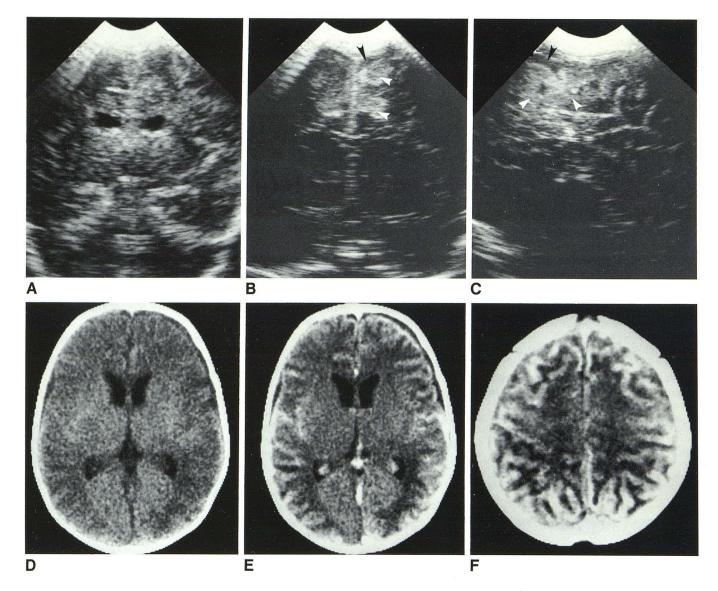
Case 1. A, Coronal sonogram with 5.0 MHz transducer. Mildly enlarged ventricles and abnormal brain parenchymal echogenicity. Magnified coronal (B) and sagittal (C) sonograms with 7.5 MHz transducer. Small amount of fluid over brain convexities (*black arrowheads*) and increased parenchymal
